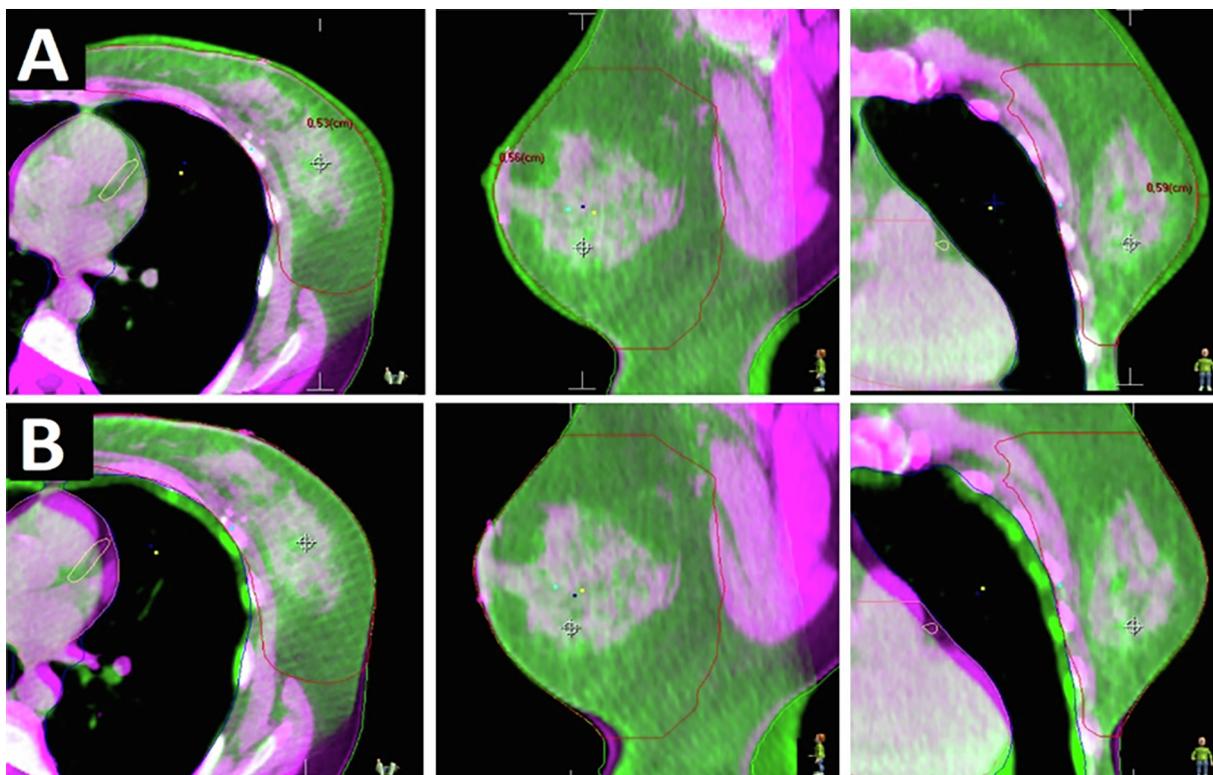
Planning CT (magenta) and CBCT (green) image registrations were performed (A) first based on the mutual information of the chest wall and (B) second only on the surface areas.
